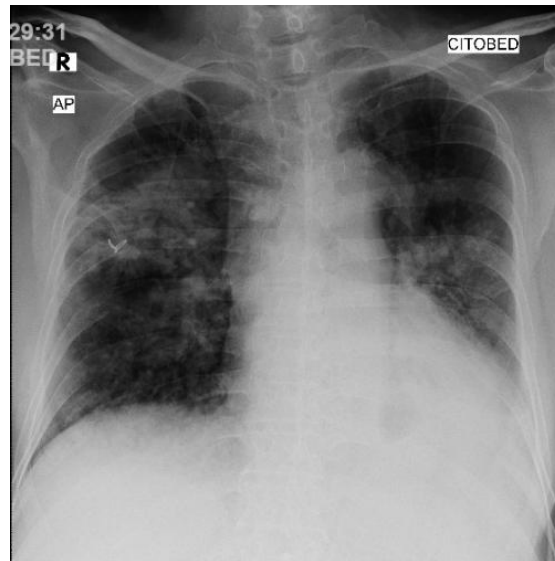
Chest X-ray image
